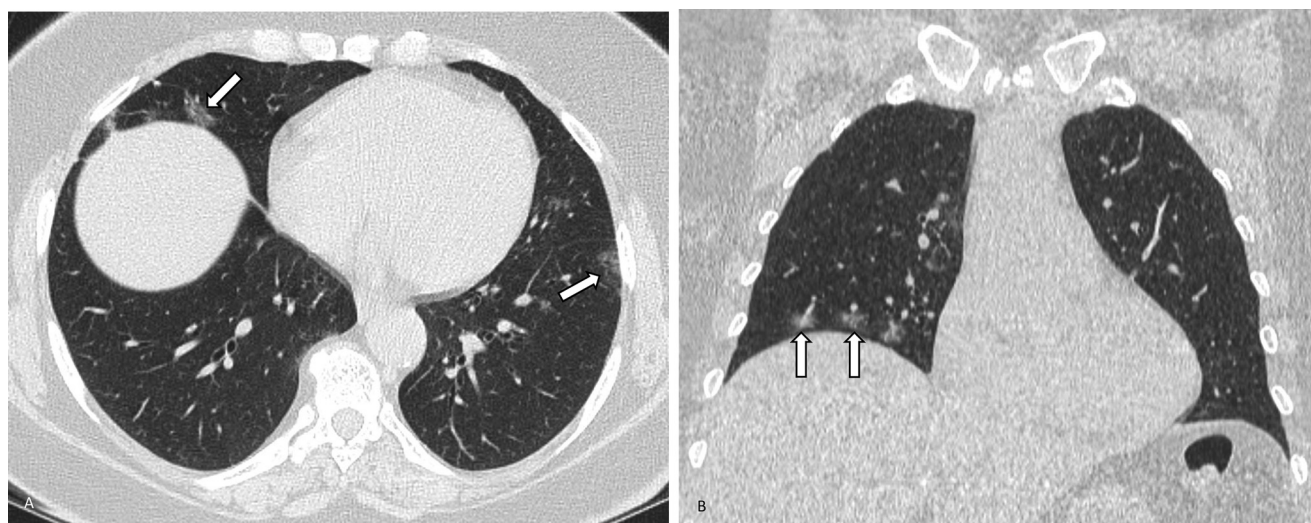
(A) Axial CT image of the chest without contrast performed 1 day after FDG PET/CT demonstrating multiple, peripheral, bilateral ground-glass opacities with rounded morphology (white arrows). (B) Coronal CT image of the chest without contrast showing ground-glass opacities with rounded morphology (white arrows) with a lower lung zone predilection.
